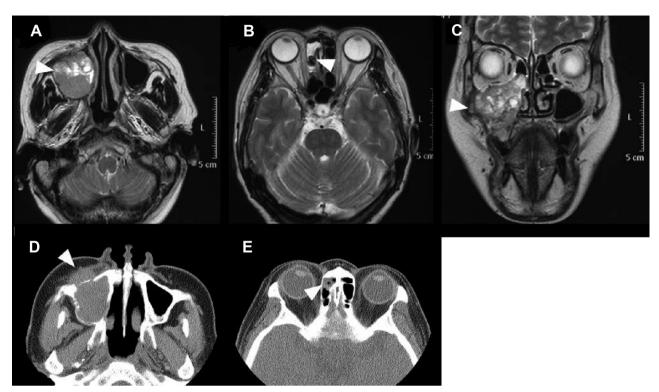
Imaging studies of the patient before chemoradiation therapy. (A–C) MRI revealed the tumor showed isointensity and hyperintensity intermixed on T2-weighted images. (D and E) CT revealed the lesion filled in the right maxillary sinus with bony erosion and extended to ethmoid sinus and nasal cavity.
